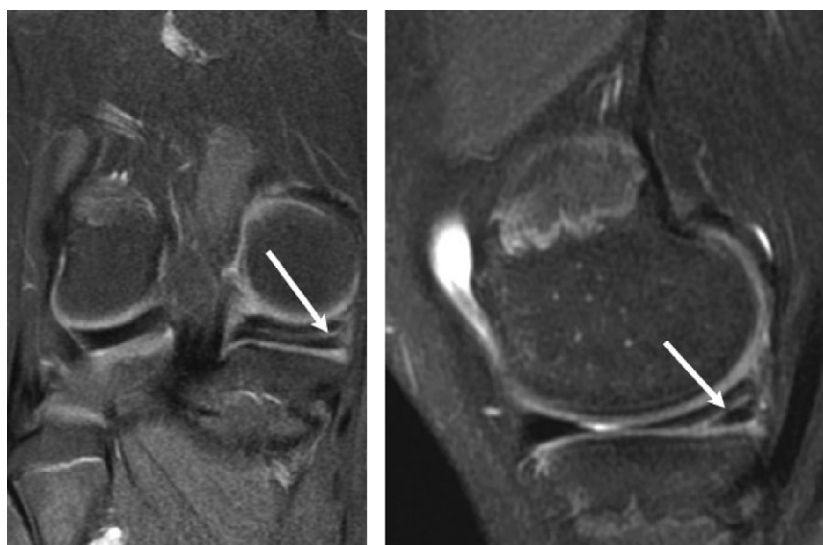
Preoperative MRI of right knee in a 14-year-old boy, wrongly interpreted as normal whereas there was a longitudinal lesion of the posterior horn of the medial meniscus.Figure 3 Preoperative MRI of right knee in a 14-year-old girl, wrongly interpreted as a lesion of the posterior horn of the medial meniscus (longitudinal on 1st reading, horizontal on 2nd).
